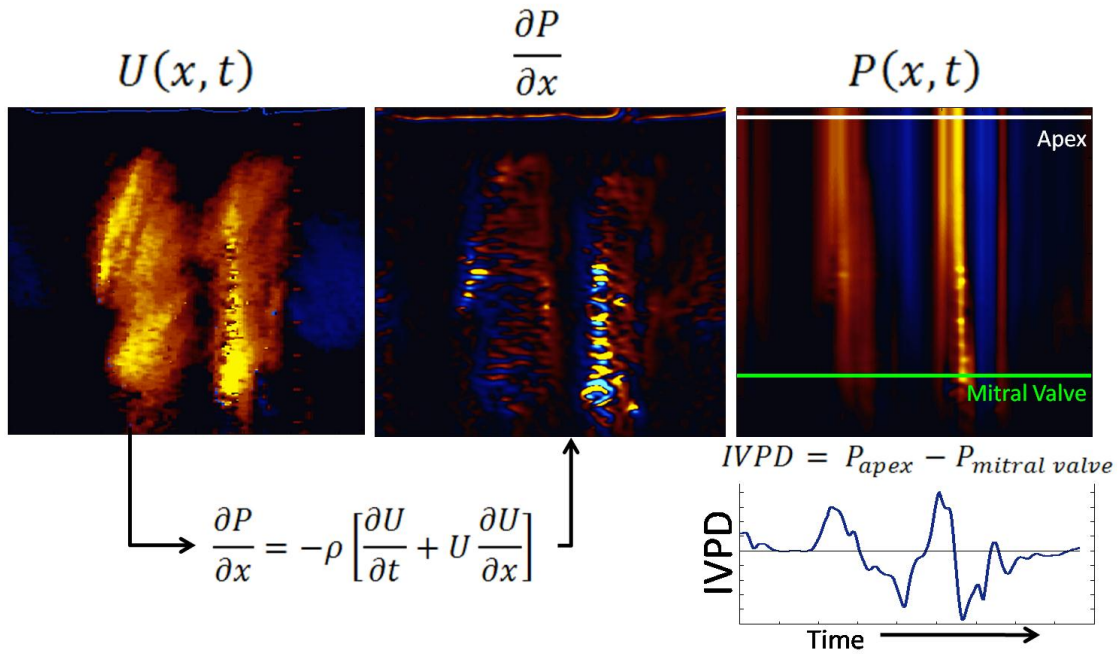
Doppler-derived IVPD calculation. The velocity field $U(x, t)$ is used to solve the Euler equation and generate a map of the pressure gradient dP/dx . This pressure gradient is integrated to solve for the pressure, $P(x, t)$. The IVPD is calculated by measuring the pressure at the apex relative to the pressure at the mitral valve location. The peak value during early diastole is recorded as the peak IVPD in mmHg.
